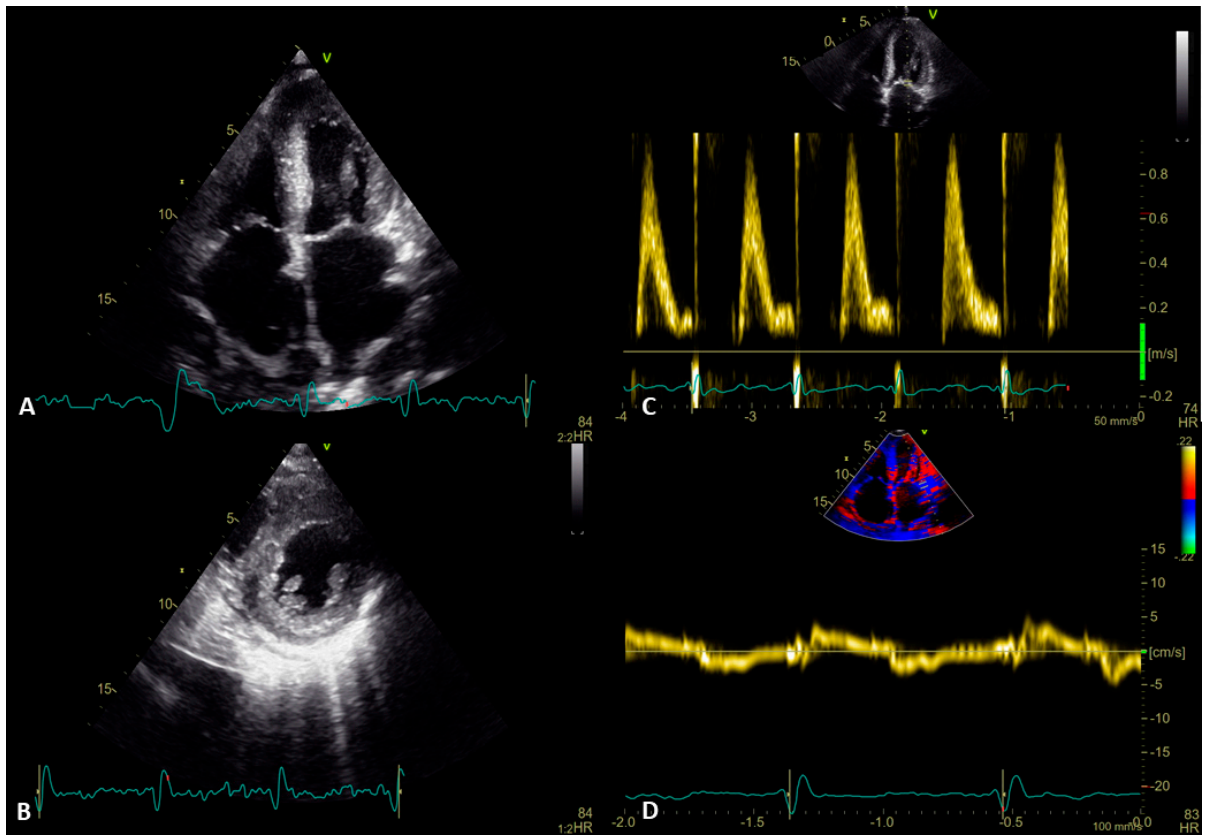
Echocardiographic image of cardiac amyloidosis. Panel A: apical four chamber view; thickening of the left ventricular wall, thickening of the heart valves, and enlarged atria thickened interatrial septum and pericardial effusion. Panel B: Parasternal short axis view: small, hypertrophied left ventricle. Panel C: Doppler inflow of the mitral valve, high velocity of E-wave, no A-wave (atrial fibrillation) showing restrictive pattern of the mitral inflow. Panel D: Tissue Doppler echocardiography – decreased velocities of the myocardium
